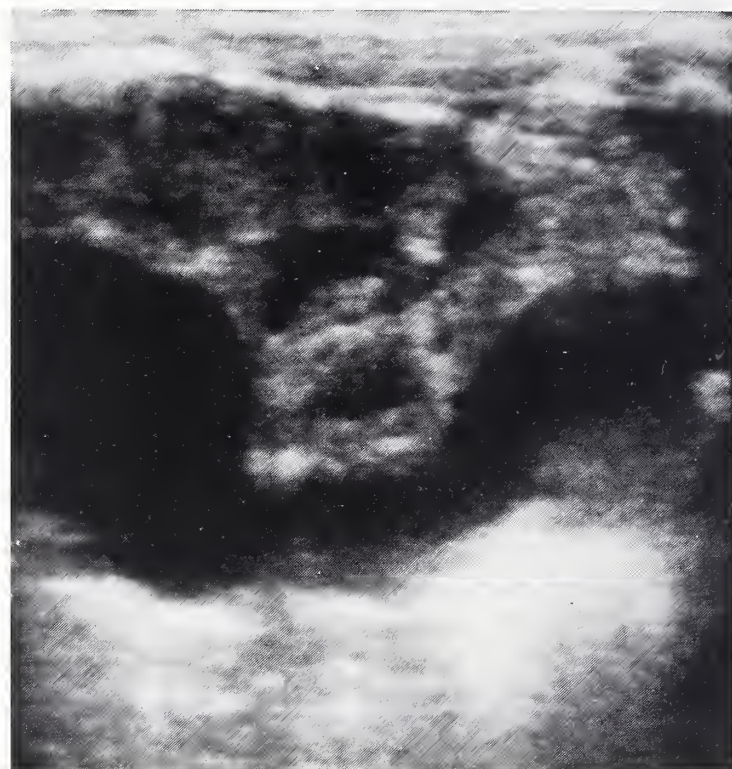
Sonogram of left kidney at birth.
